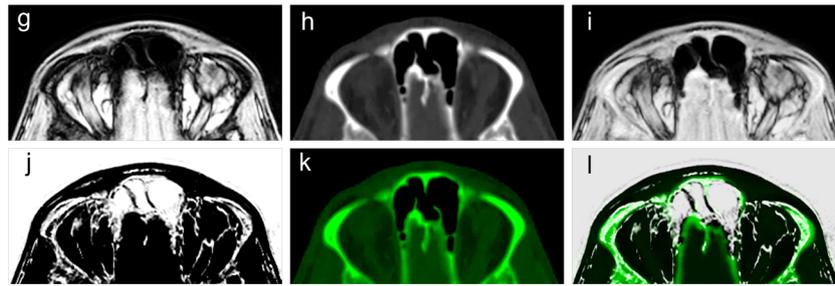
First row: axial cross section MR imaging a, axial cross section CT imaging b and fusion of both images c at orbital height; Second row: inverted axial cross section MR imaging d, colored axial cross section CT
